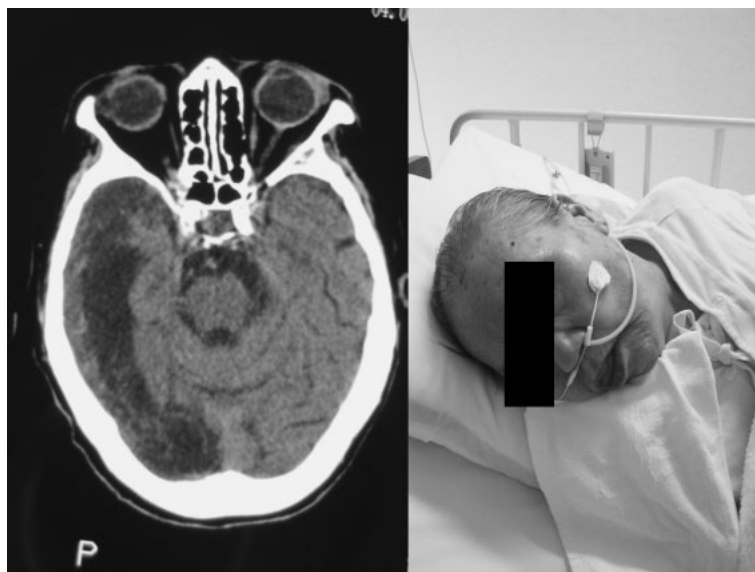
Plain brain CT of 89-year-old woman revealed large low-density cerebral infarction area in the right lateral lobe. She was fed via a stomach tube in a condition close to complete disuse syndrome. All her ADL were performed by care workers and nurses. Despite these conditions, her HRV indices were changed markedly during music therapy. Details are explained in the text.
